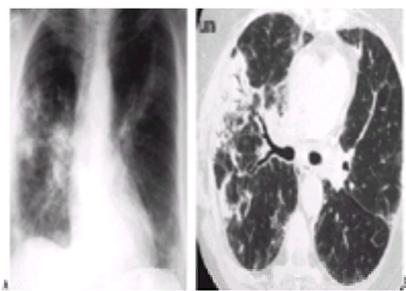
A: Bronchiolitis obliterans organizing pneumonia. PA chest radiograph from a 67-year-old woman demonstrates patchy bilateral infiltrates. She had been given three prior courses of antibiotics by her personal physician during the preceding 7 weeks because of persistent cough, fever, and dyspnea, with no improvement. Changes revealed by transbronchial lung biopsy were consistent with BOOP, and corticosteroids (1 mg of prednisone per kilogram of body weight per day) were initiated. B: CT demonstrates dense alveolar infiltrates with striking air bronchograms in the periphery of the right lung.
